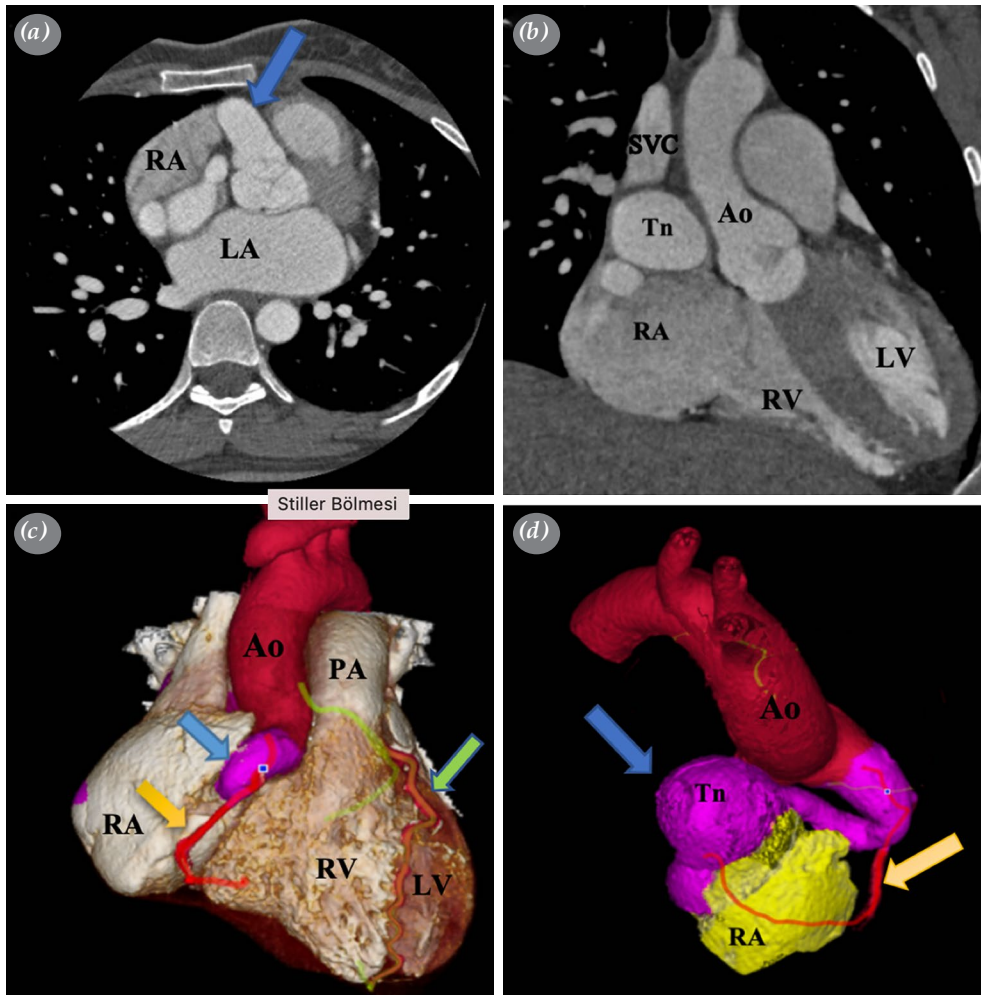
(a-d) Cardiac computed tomography demonstrating the fistula on multiplanar reconstructions and volume rendering images. (a) The aneurysmatic right coronary ostium, which continued a tunnel (blue arrow) in axial images. (b) The curved reformat image displays the tunnel (blue arrow) draining into the right atrium as a coronary artery fistula and the aneurysmatic dilatation at the termination. (c) The volume rendering image reveals the right coronary artery (yellow arrow) separating from the tunnel (blue arrow) and following the posterior atrioventricular sulcus. The left coronary artery is shown to be normal (green arrow). (d) The right atrial appendix subtracted from the volume rendering images, allowing the visualization of the entire tunnel, the right atrium, and the fistula.
